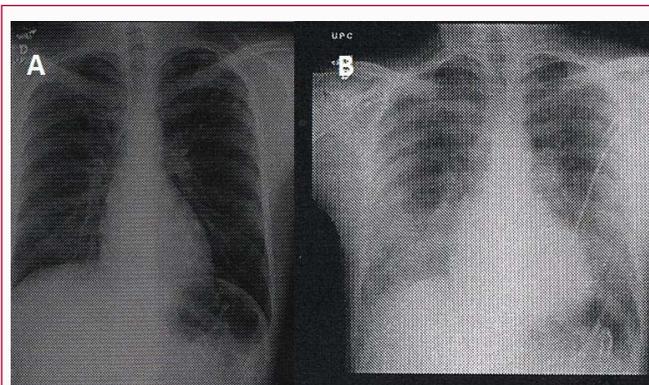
Chest X-ray: A) At admission, described as normal. B) During desaturation, compatible with pulmonary edema.
